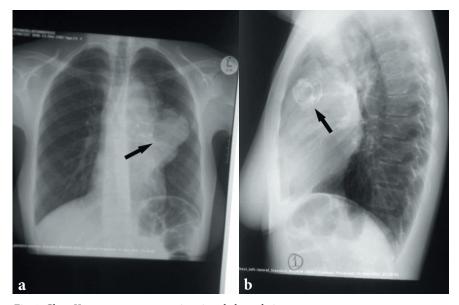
Chest X-ray: a. postero-anterior view; b. lateral view.
